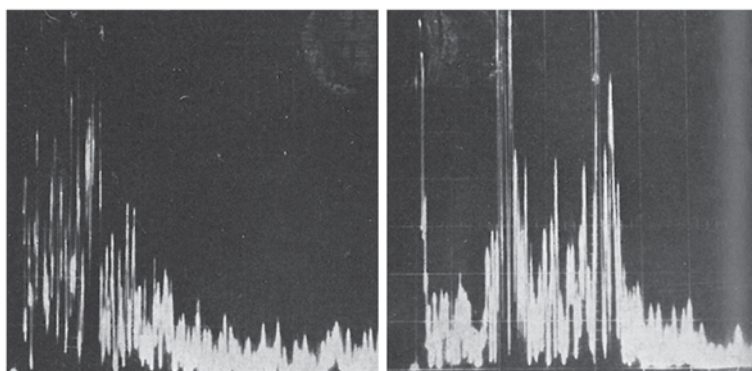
A-scan ultrasound of normal testis (*left*) vs neoplasm (*right*) [34]
